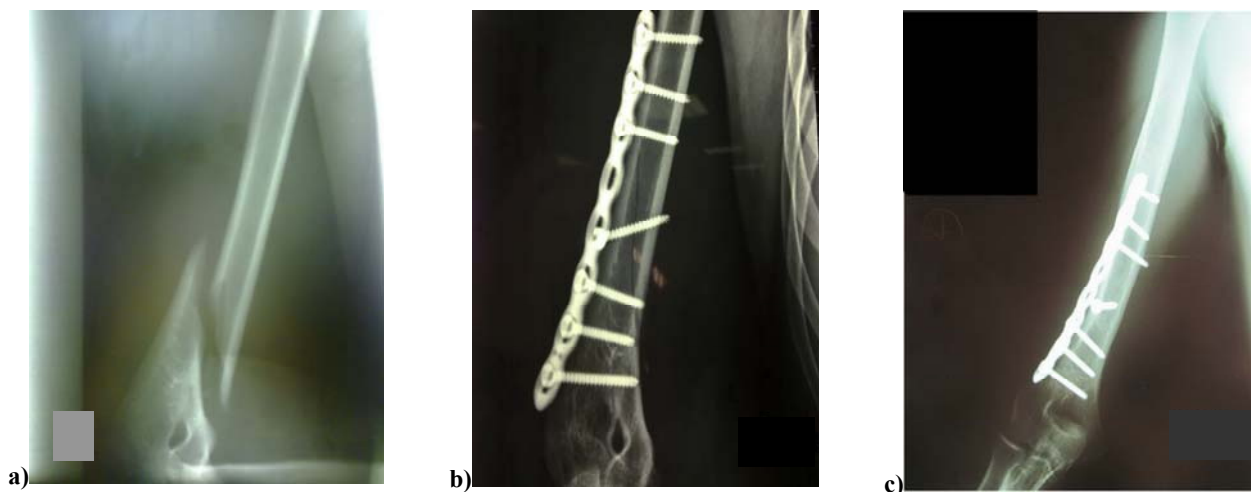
Patient A: a) preoperative radiography done at the Emergency Room Department on the day of injury; b) and c) postoperative radiography.
